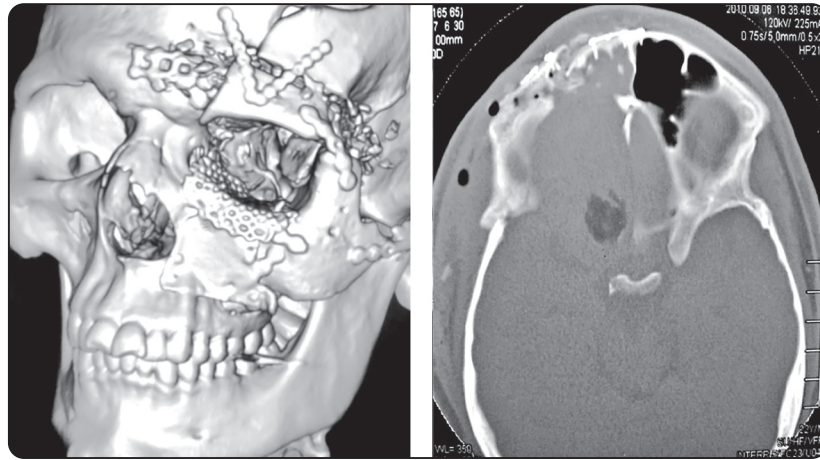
1-week postoperative CT after FS obliteration & anterior table reconstruction
